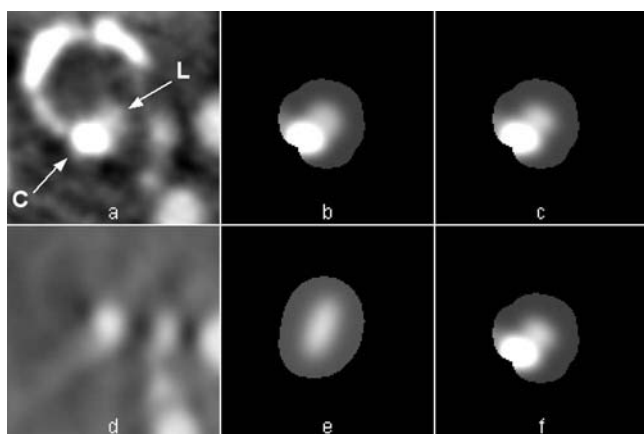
(a) CTA image at the site of maximal stenosis of patient 1 (Fig. 9, 13th image of stenosis segment at 25 mm); the lumen is indicated with an L and the calcification with a C; (b, c, and f) fitted images using all parameters (b) and prior knowledge of three (c) and two (f) parameters. (d) 3DRA image at the same site with nearly invisible calcification; note the streak artifacts. (e) fitted 3DRA image. Each image measures 12.8×12.8 mm². The window center is 200 HU and the window width is 400 HU for (a)–(c) and (f); for (d) and (e), settings were chosen to obtain approximately the same gray values for artery and background.
